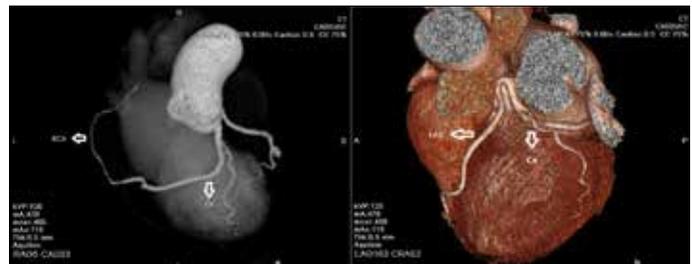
Multidetector computed tomography (64-slice) views of single coronary artery
